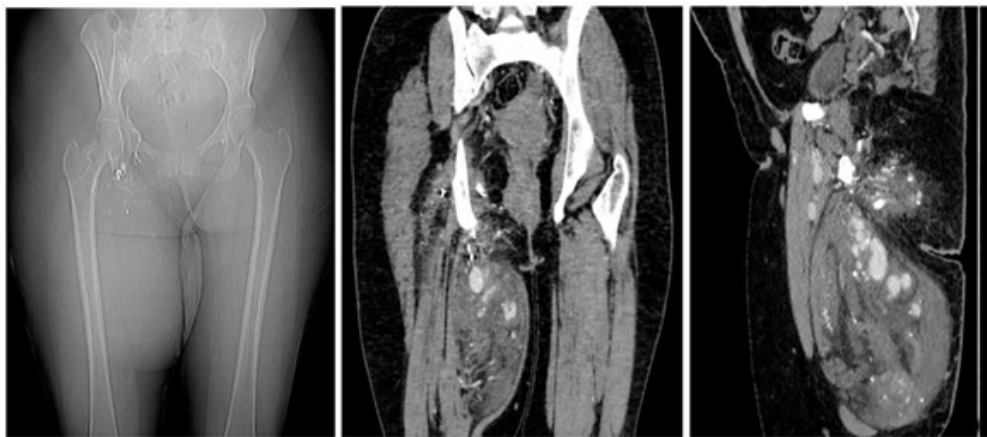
CT angiography post embolization. Coil and glue cast within right thigh AVM with non-opacification of feeders or AVM nidus. Few dilated venous channels were still seen within right thigh AVM.
